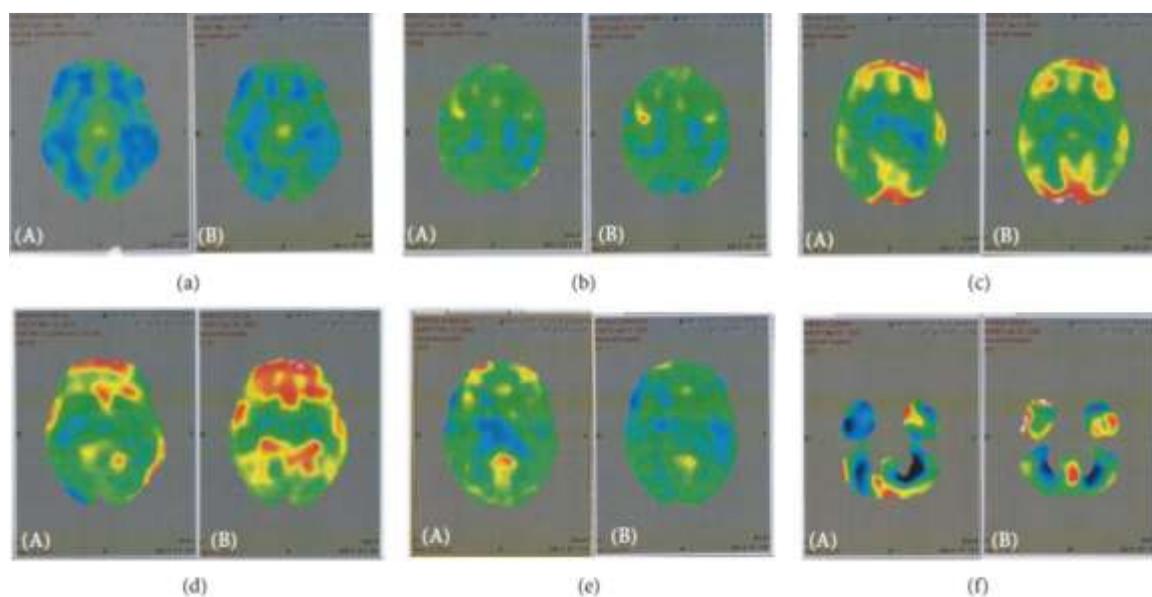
Improvements in PET-CT scan images of (A) pre and (B) Post intervention showing increased metabolic activity in various areas. Blue areas indicate hypometabolism, green areas indicate normal metabolism and yellow areas indicate slightly high metabolism and red areas indicate high metabolism.*
